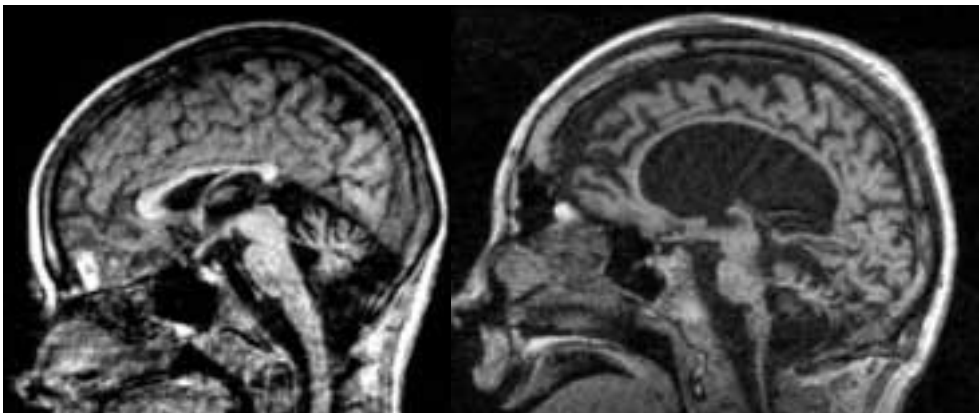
A sagittal T1-weighted MPRAGE image of a 8.8-year-old patient with vLINCL_{Fin} on the left and of a 16.7-year-old patient on the right. In the younger patient, the cerebrum is only slightly atrophic, whereas the corpus callosum is thin and cerebellum moderately atrophic. In the older patient, the cerebrum and cerebellum are extremely atrophic and corpus callosum is extremely thin. Note also the thickening of the skull in the older patient.
